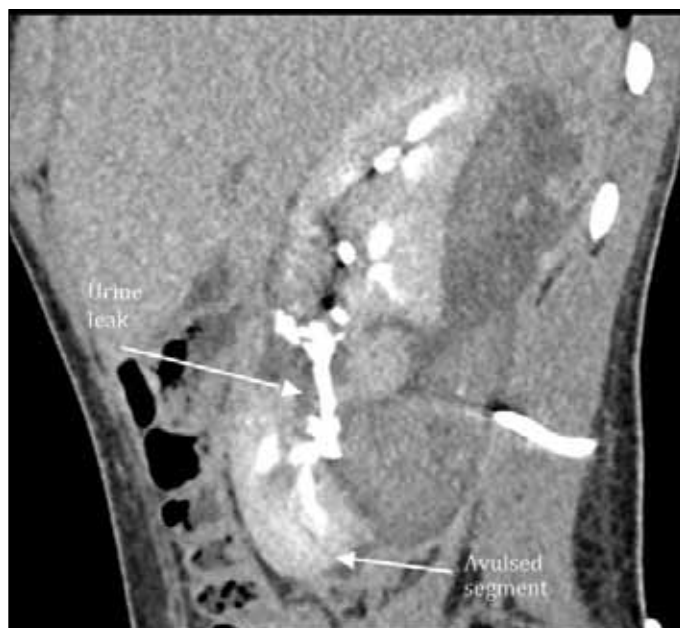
Delayed computed tomography scan showing urinary leak.
